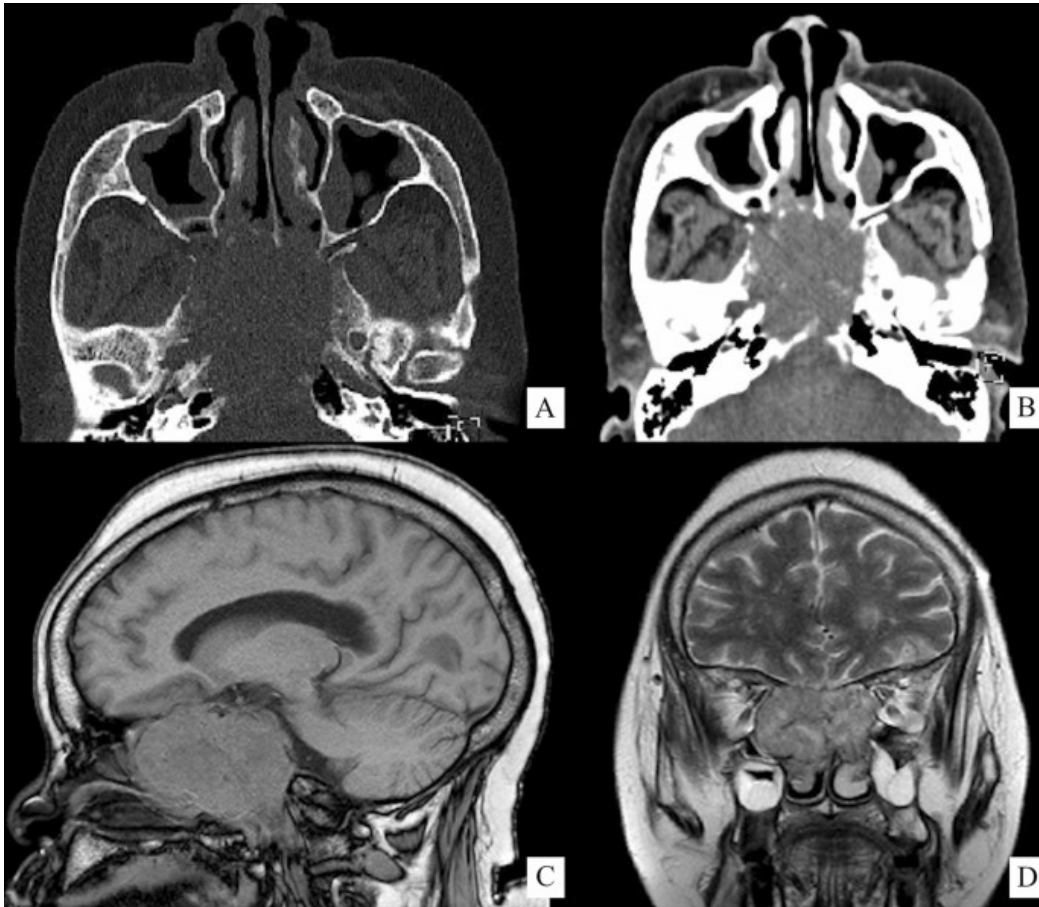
Case 7: (A) Axial bone and (B) soft tissue levels of CT imaging showing a poorly demarcated osteolytic lesion that resulted in significant bone destruction with intracranial extension at the superior margins. Anteriorly, the mass extended to involve the sphenoid, ethmoid and maxillary sinuses. (C)
